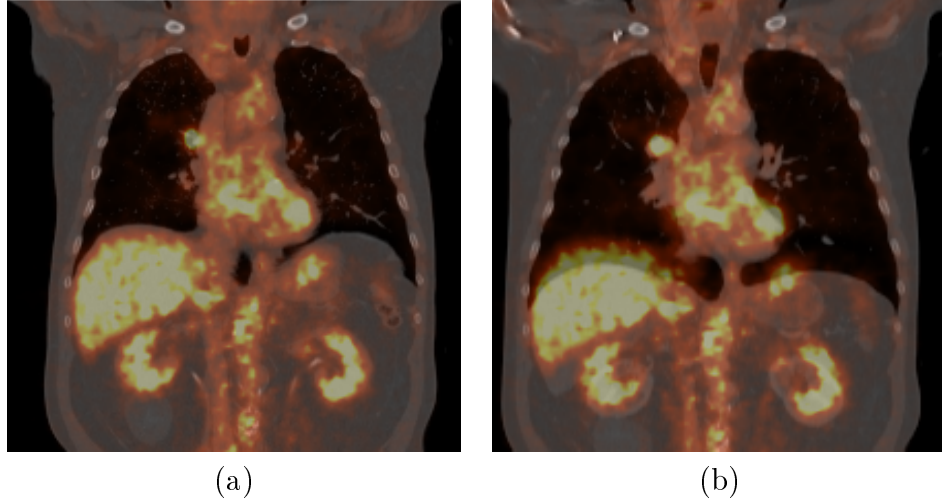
(a) Fused PET/ AC-CT image (inherently registered as they are acquired from the same scanner) (b) Fused PET/D-CT (contrast-enhanced) image without registration.
